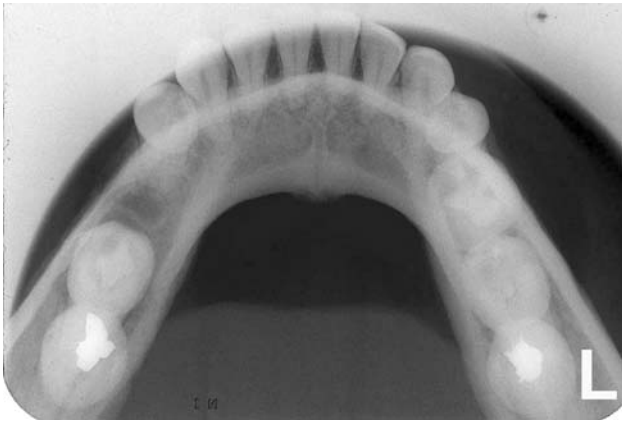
Occlusal radiograph
